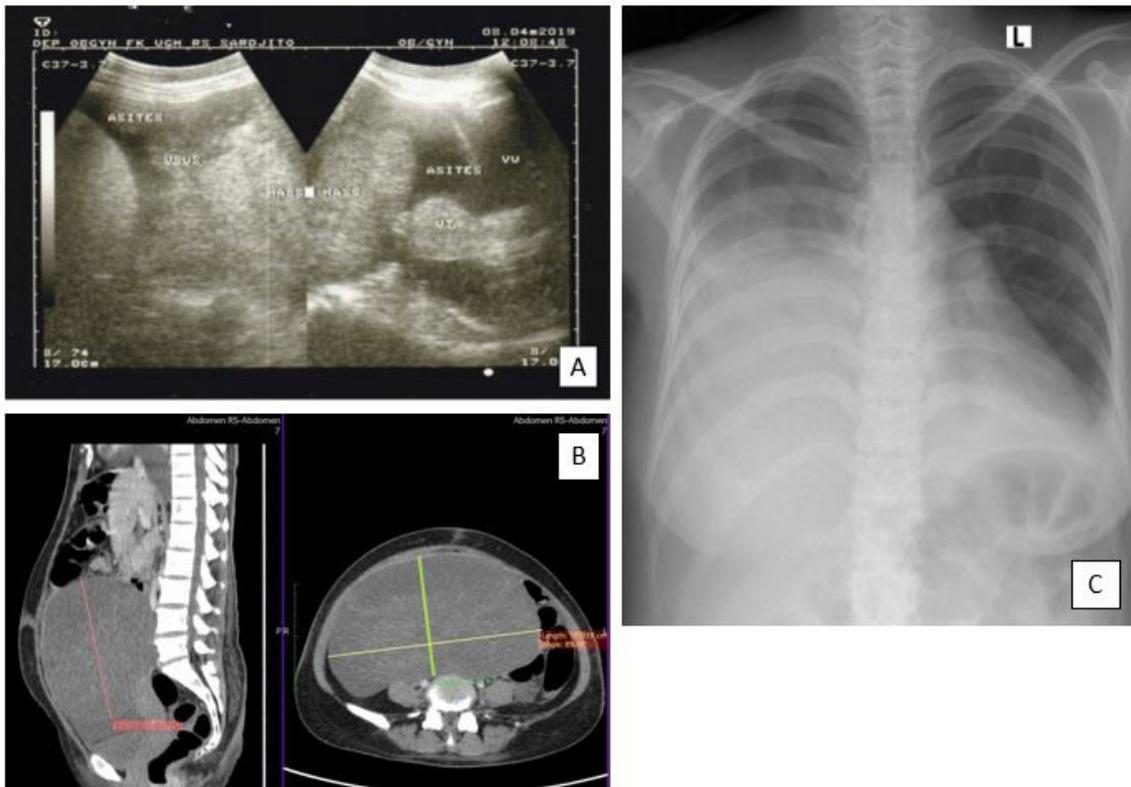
Radiological examination (A). Transabdominal ultrasound and, (B). Abdominal CT scan examination revealed a right ovarian solid tumor sized $20 \times 11 \times 15 \text{ cm}^3$ accompanied with ascites. (C). Chest X-ray showed a right pleural effusion.
